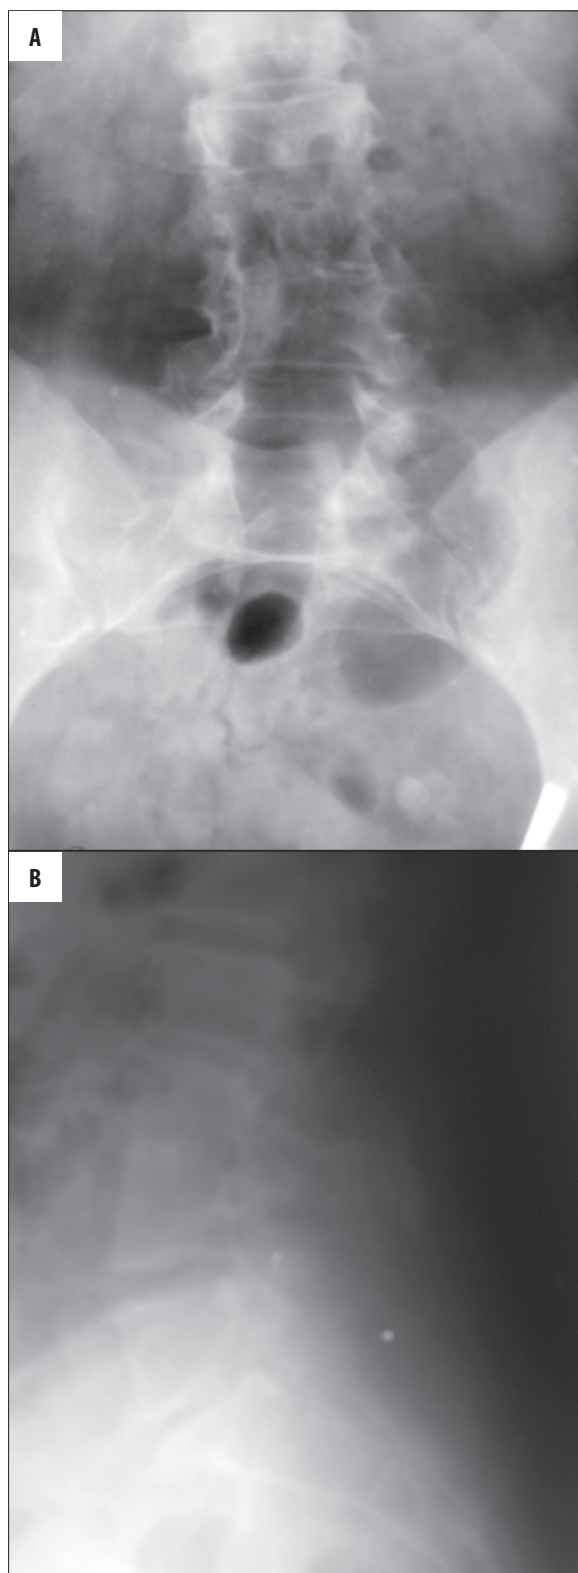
X-ray of the lumbar spine: anterior-posterior plane (A), lateral plane (B). Scoliosis, partial fusion of the L3–L4 bodies, and defective fusion of posterior spinal bony elements within L5–S1.
